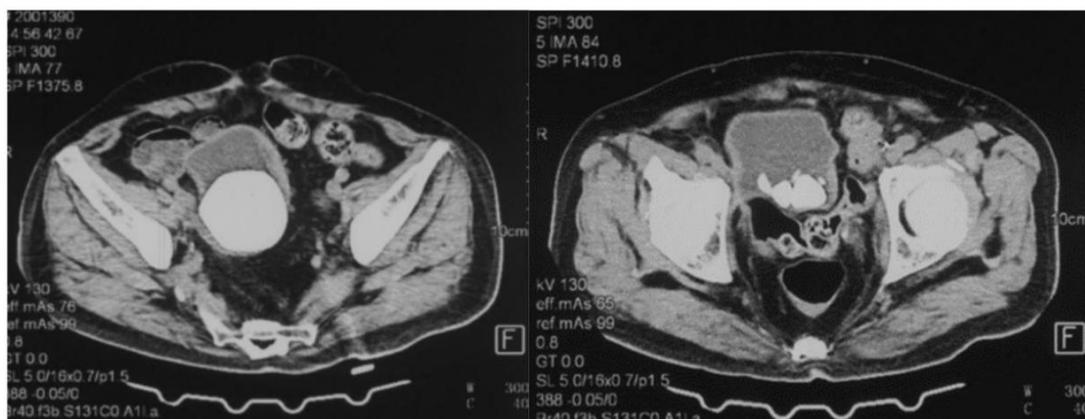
CT showed multiple high-density stone shadows in the bladder, the largest being 6 cm in diameter.
